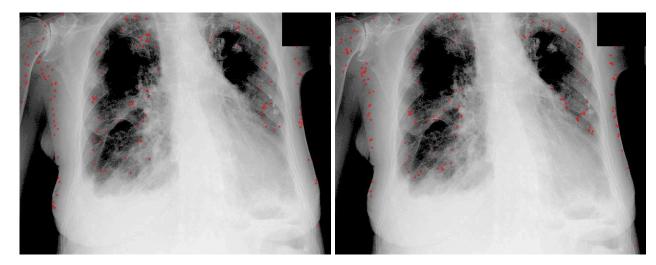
GFA and GCSA recognition over pneumonia on the original image from the X-RAY apparatus
